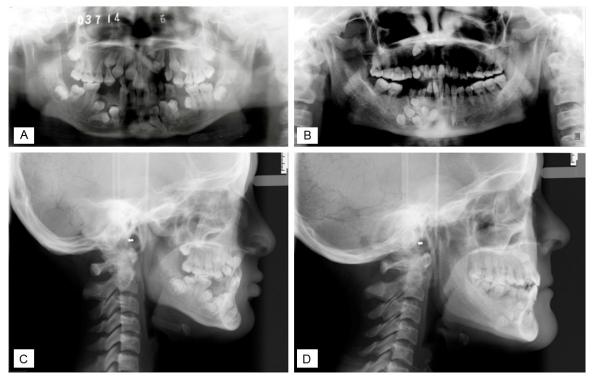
Panoramic radiograph showed many impacted and unerupted teeth (permanent or supernumerary), in the proband (A) and her mother (B). Cephalometric X-ray showed many impacted and unerupted teeth (permanent or supernumerary) and dysplastic nose bone in the proband (C) and her mother (D).
